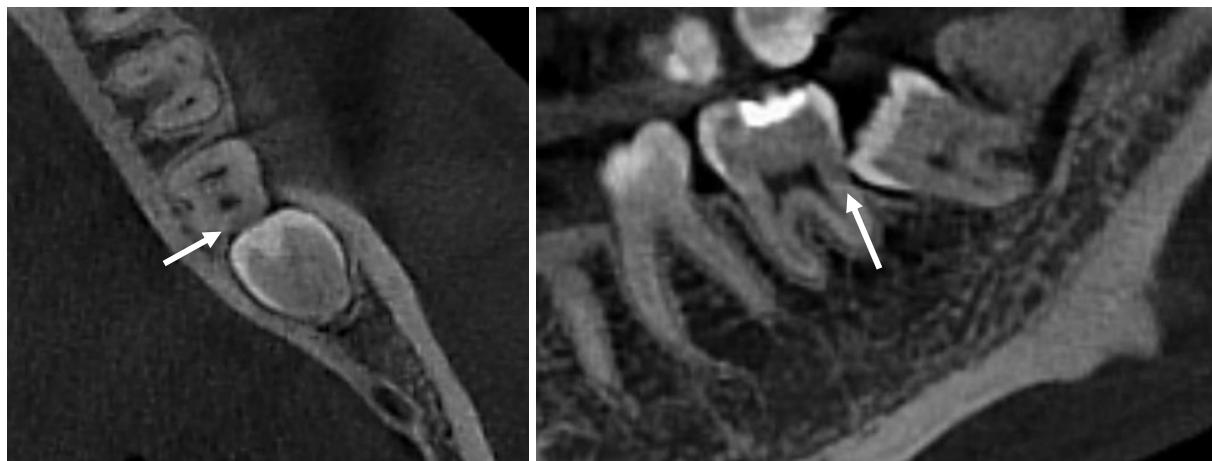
An impacted left mandibular third molar shown in cone beam computed tomography (CBCT) images. (A) Axial reconstruction. (B) Sagittal reconstruction. Arrows indicate external root resorption detected on the CBCT images.
